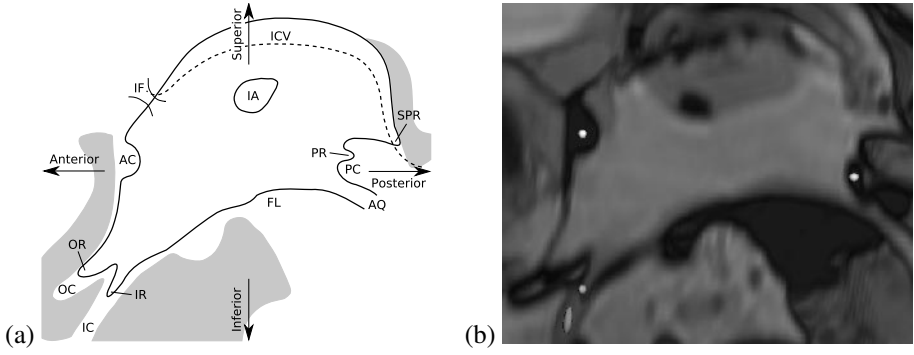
(a) Anatomy of third ventricle. Extraventricular CSF is marked in light gray. AC Anterior commissure, AQ Cerebral aqueduct, FL Floor of the third ventricle, IA Interthalamic adhesion, IC Infundibular chiasm, ICV Internal cerebral veins, IF Interventricular foramen, IR Infundibular recess, OC Optic chiasm, OR Optic recess, PC Posterior commissure, PR Pineal recess, SPR Suprapineal recess (b) Selected landmarks overlaid on a MRI dataset.
